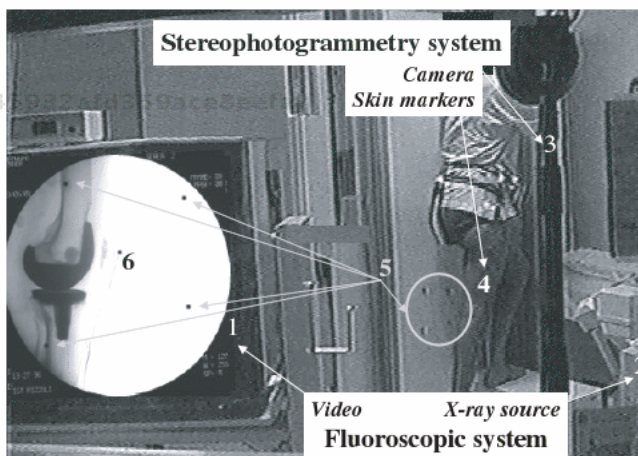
Experimental setup. (1) Real-time visible feedback of the fluoroscopic images acquired; (2) X-ray source of the fluoroscope; (3) one of the five cameras of the stereophotogrammetric system; (4) skin markers on the lateral aspect of the thigh and the shank; (5) the four specialized radiopaque/reflecting markers for spatial registration; (6) the specialized radiopaque/reflecting marker for temporal synchronization.¹⁶²
